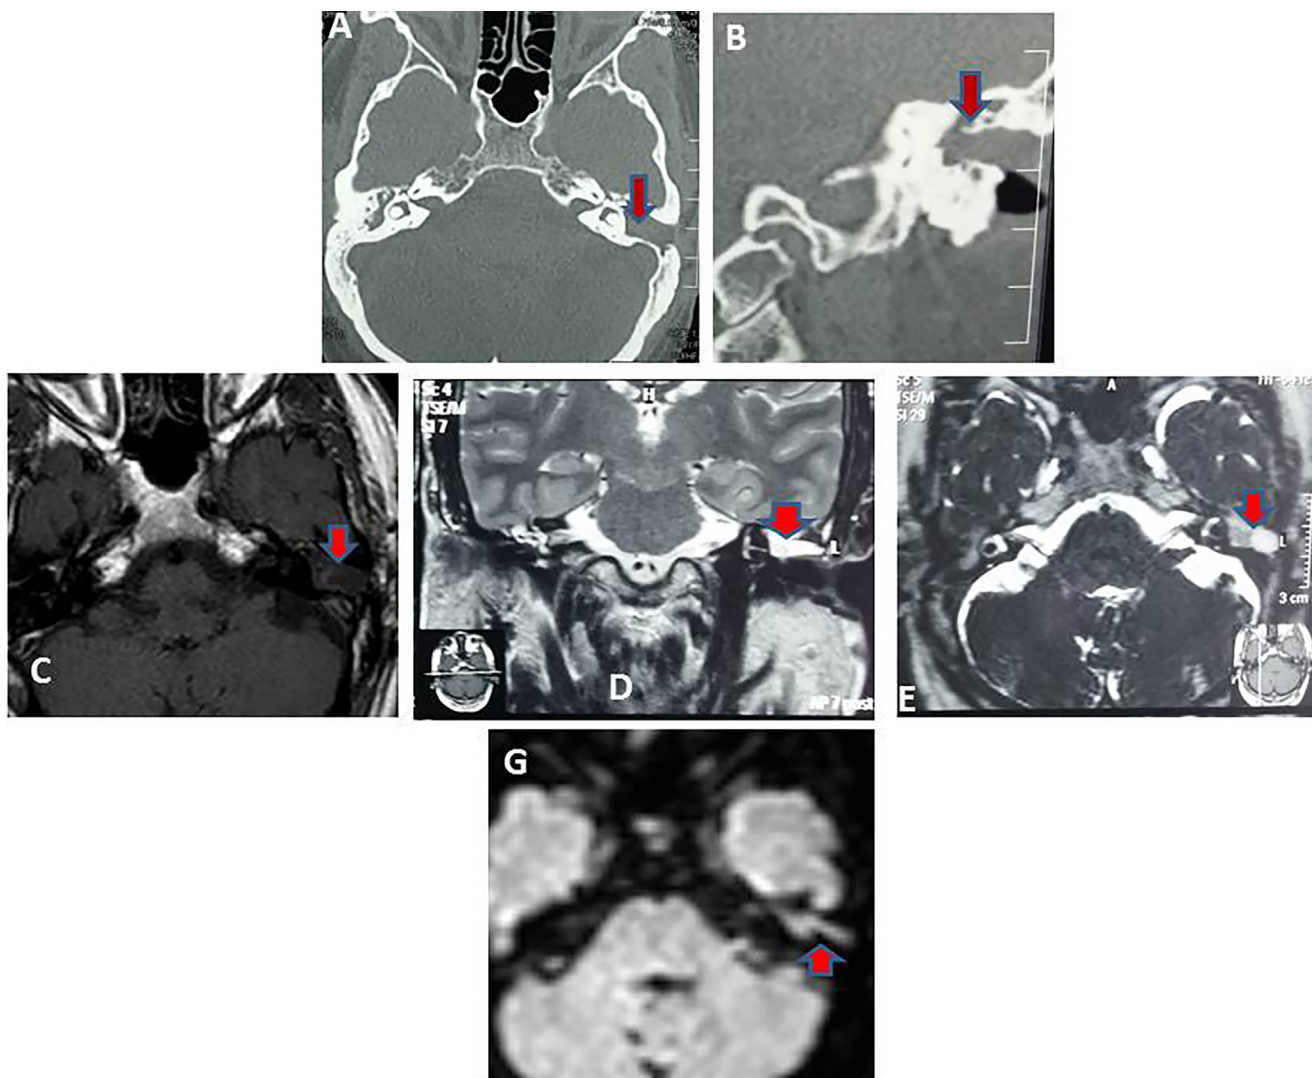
Recurrent cholesteatoma in the left middle ear with CSOM at the right of a 38 years old man who underwent CWU middle ear surgery. (A and B) Axial and coronal CT cuts showed complete opacification of the right middle ear cleft by tissue density lesion associated with eroded ossicular chains (red arrow). (C) Axial T1WI, (D) Coronal T2W SE and (E) Axial CISS showed a soft tissue lesion in the right middle ear cleft of low signal at T1WI and high signal intensity at T2WI and CISS. (G) Axial DWI obtained with a b factor of 1000 s/mm² showed high signal intensity of the cholesteatoma (red arrow) at the left with no abnormal signal at T2WI. The size of the lesion is 18 mm at CT and 11 mm at DWI.
